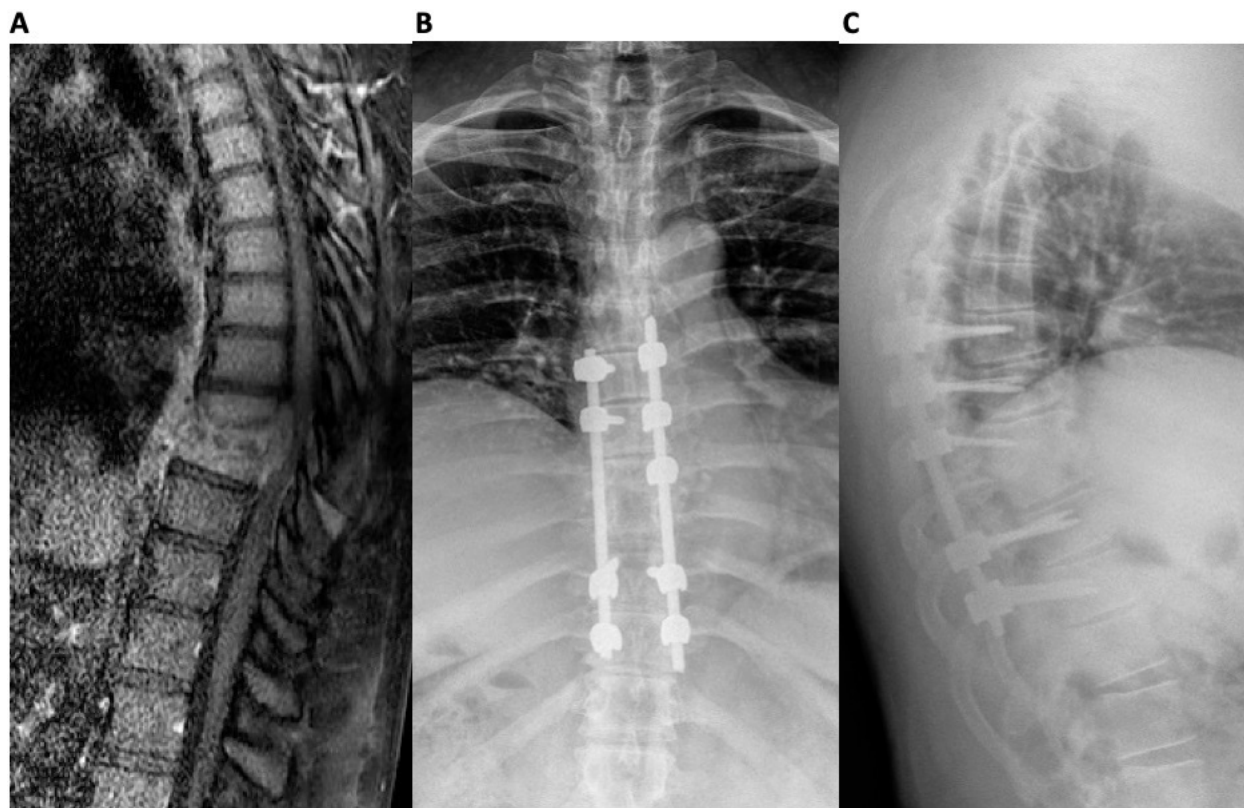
Preoperative magnetic resonance image (A) demonstrates focal T2 hyperintensity at T8–T9 consistent with discitis with an associated epidural phlegmon resulting in central stenosis. Postoperative radiographs (B and C) demonstrate a fusion of the T8 and T9 vertebral bodies 6 months after posterior fixation without debridement.
